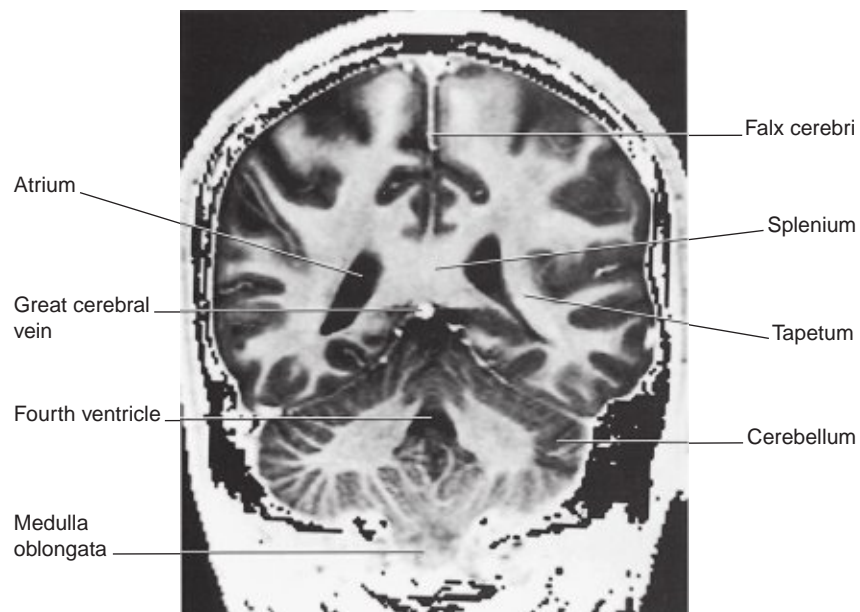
Coronal MRI 'slice' at the level indicated at top. (From a series kindly provided by Professor J. Paul Finn, Director, Magnetic Resonance Research, Department of Radiology, David Geffen School of Medicine at UCLA, California, USA.)
